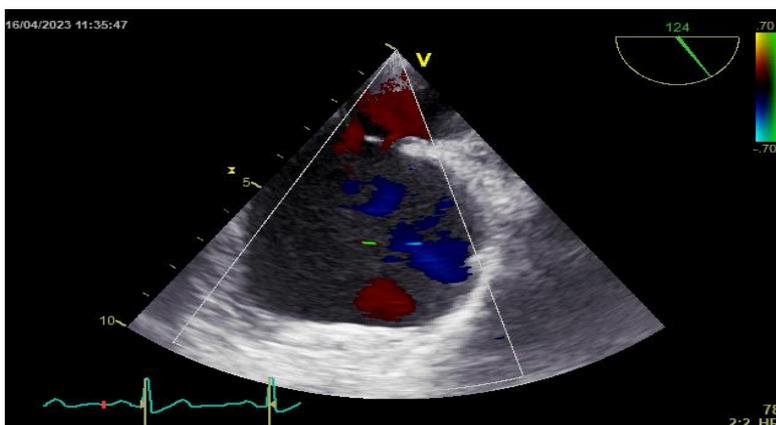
TEE image showing the passage of the R-L shunt in color Doppler through the PFO.
